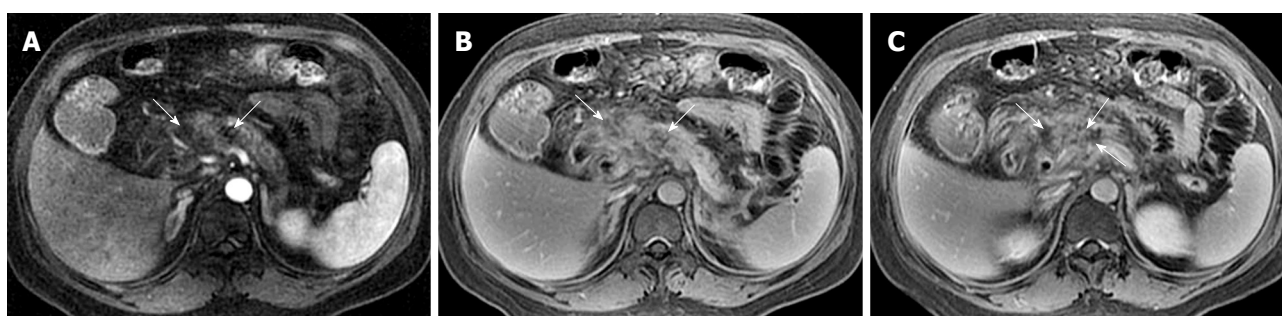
43-year-old woman with acute pancreatitis. Contrast-enhanced axial T1-weighted images during arterial phase (A) and late venous phase (B, C) show spotted, patchy non-enhanced areas in the pancreatic head and body (arrows).
